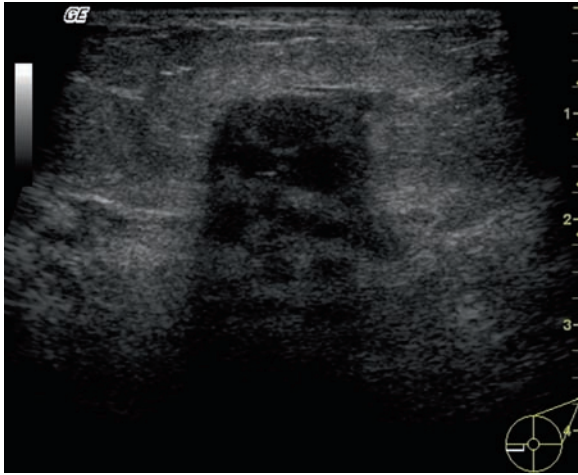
Ultrasound of a breast cancer: note the irregular margin and dense acoustic shadow in contrast to Figs. 6.11 and 6.15
